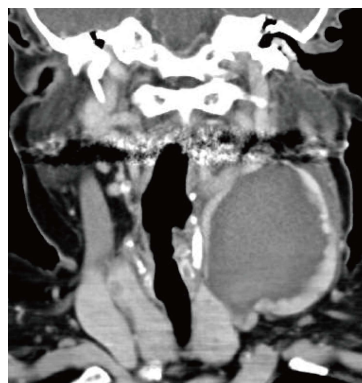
Coronal computed tomography of left internal jugular vein aneurysm.
